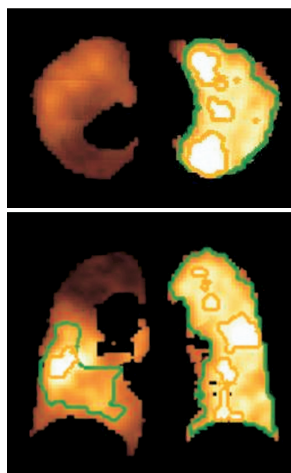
The percentile single-photon-emission computed tomography (SPECT) images (upon applying histogram equalization on the original SPECT images) in a single case. The increase of the perfusion is represented by the intensity of the images. The F50 and F90 lung are highlighted in green and orange colors, respectively.
